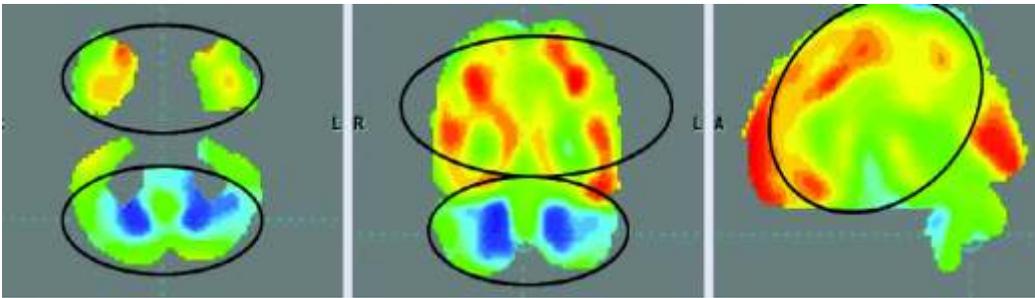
PET-CT scan after stem cell therapy showing reduction in the metabolic activity of the cortical lobes and increased metabolic activity in bilateral cerebellar lobes hence highlighting the balancing effect of cellular therapy
